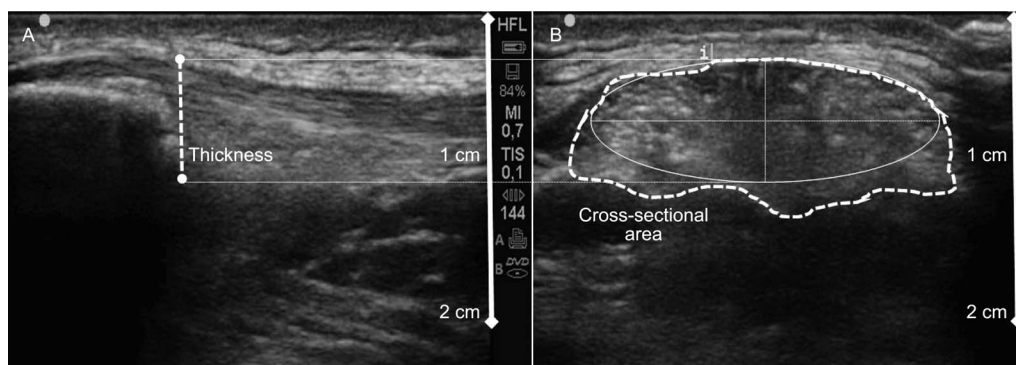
Morphologic measures in an ultrasonographic image of a tendon without abnormalities. A, Longitudinal view to measure thickness. B, Cross-sectional view and cross-sectional area delimited by semiautomatic adaptive contours.
